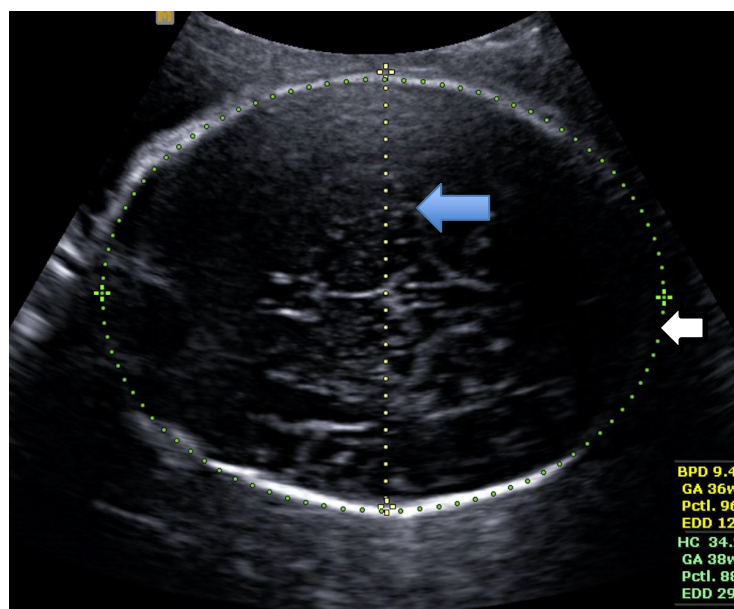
Ultrasound image of fetal biparietal diameter (BPD; blue arrow) and head circumference (HC; white arrow). Participant image used with permission.
